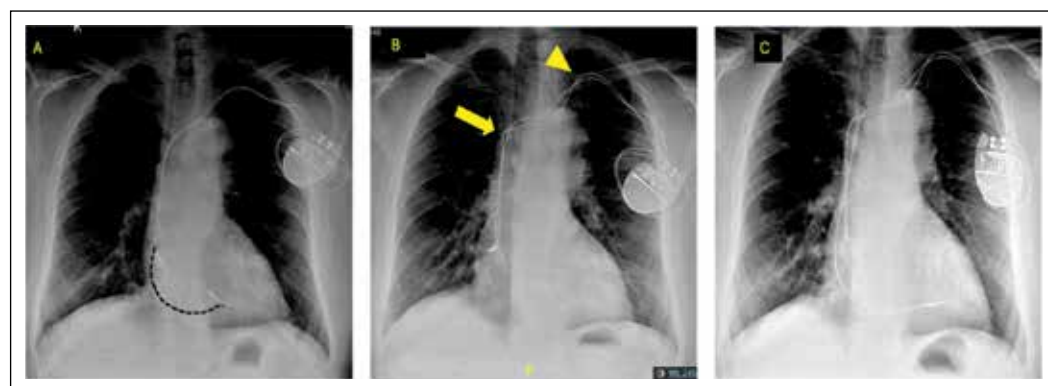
A series of frontal radiographs of a single patient with sick sinus syndrome who underwent dual chamber pacemaker insertion- depicts the importance of loop creation. Panel A shows the final position of the leads with clearly less loop for the ventricular and atrial leads. The dashed line indicates the ideal position for the ventricular lead. After one week of discharge, during 1st visit, a repeat frontal radiograph shows grossly displaced loops and the formation of SVC (arrow) and subclavian loops (arrowhead). Interrogation revealed loss of R wave and high capture threshold of ventricular lead with normal atrial lead parameters (B). Panel C shows the final position of the ventricular lead after repositioning, showing adequately formed RA (*), SVC and subclavian loops. The atrial lead was densely adhered to and could not be repositioned. Given normal acceptable parameters, the lead position was accepted.
